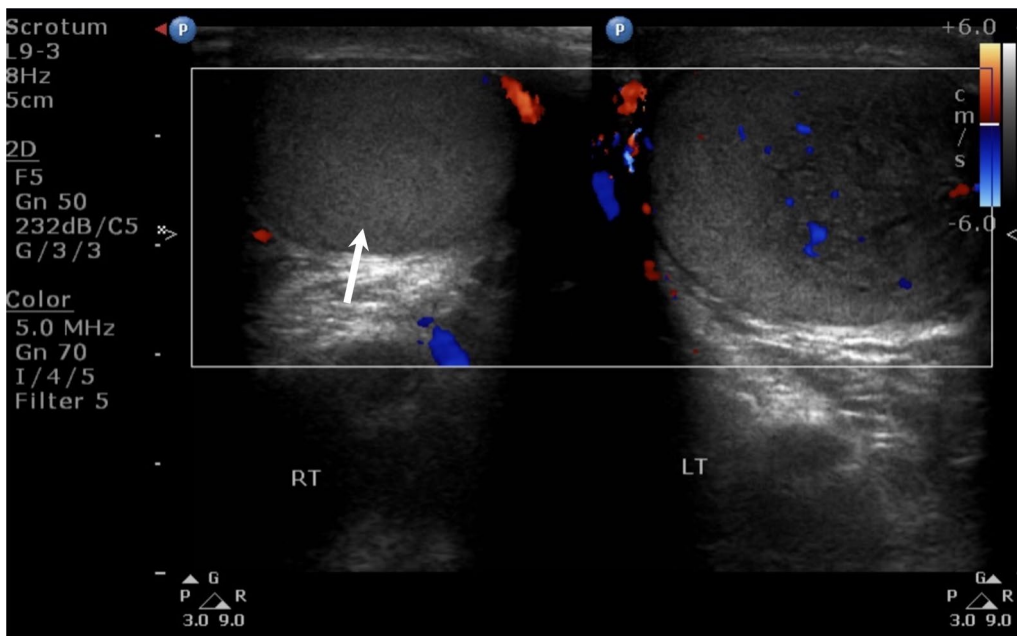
Ultrasound (longitudinal view) of the right testis shows that it is normal in size and homogenous in appearance
